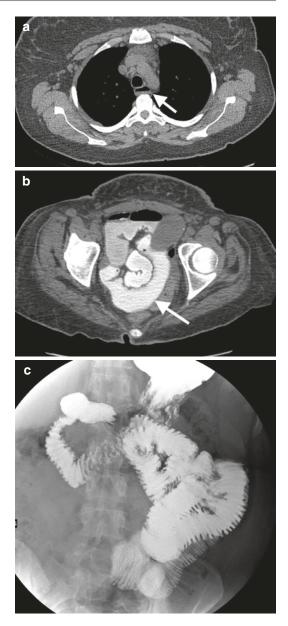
Gastrointestinal manifestations of scleroderma. (a) Axial CT with esophageal dilatation in scleroderma patient, (b) dilated small bowel loops (*arrow*) with hypomotility on axial CT, (c) hidebound pattern on a barium follow-through study in a different patient
